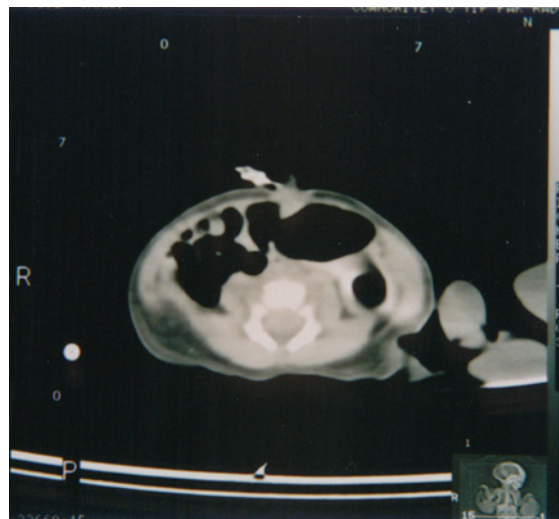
Abdominal CT: Posterior arc defect in lumbar vertebrae.
